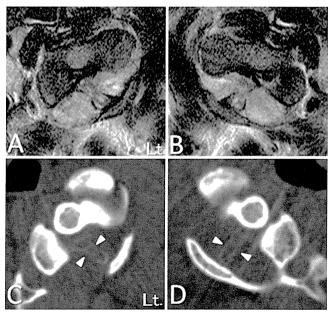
Case 1. Axial T2-weighted MRI and CTM scans at C1–2 on rotation of the cervical spine revealing bilateral intracanal protrusion of the tumors compressing the lateral side of the spinal cord (rotation to the right [A and C] and rotation to the left [B and D]). The arrowheads show the indentation of the dural tube.
